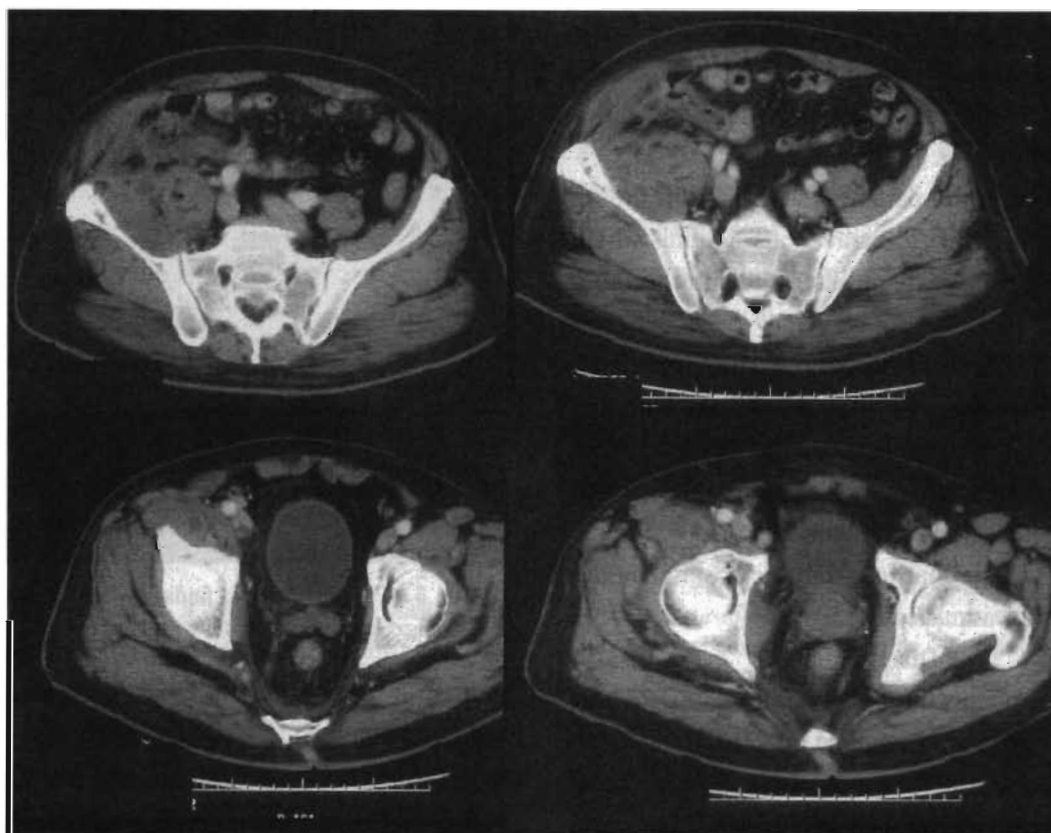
The computed tomogram of the admission day revealed abscess region in the right lower abdomen to the right thigh
